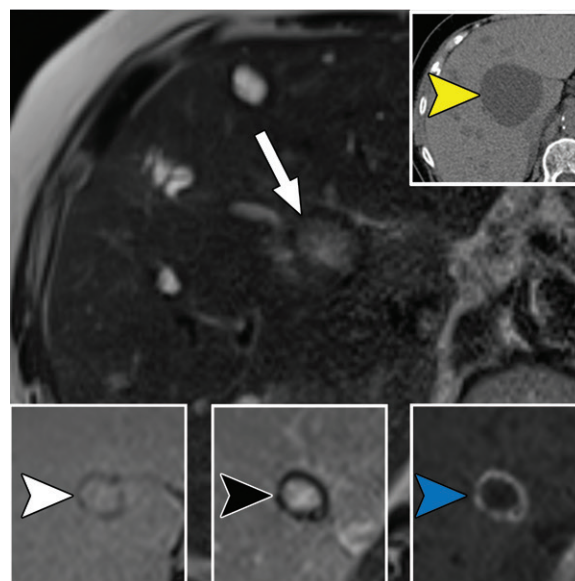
Magnetic susceptibility as a problem-solving tool in an 80-year-old woman with an involuted hemorrhagic hepatic cyst. Axial T2-weighted MR image shows an intermediate-T2-signal-intensity hepatic lesion with a thick hypointense rim (arrow). Gradient-echo images with a TE of 2.38 msec (bottom left inset) and 15.6 msec (bottom middle inset) show accentuation of hypointense signal with longer TE (white and black arrowheads) consistent with magnetic susceptibility from a hemosiderin rim from prior hemorrhage. An R2* map (bottom right inset) generated from multiecho gradient imaging shows corresponding hyperintensity (blue arrowhead), providing similar information with a single sequence compared with having to review sequential data from multiple echoes. Comparison with an axial CT image from 3 years prior (top right inset) shows a larger cyst in this location (yellow arrowhead) that hemorrhaged and involuted in the interim.
